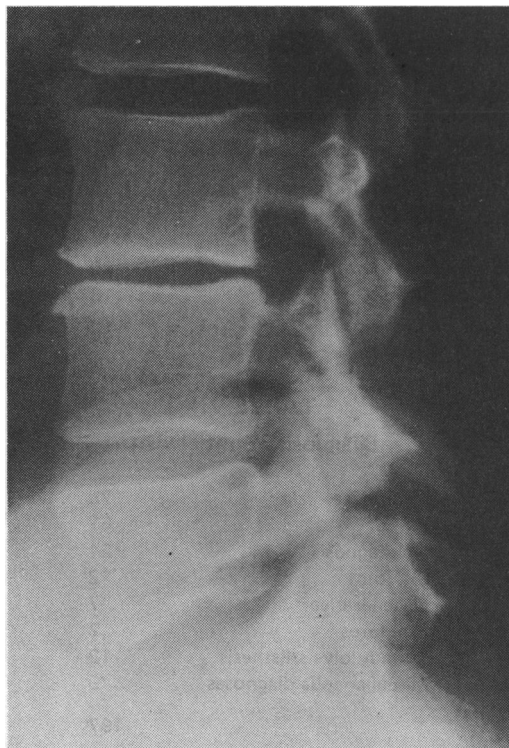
Lateral radiograph. Type IIb Spondylolisthesis.
